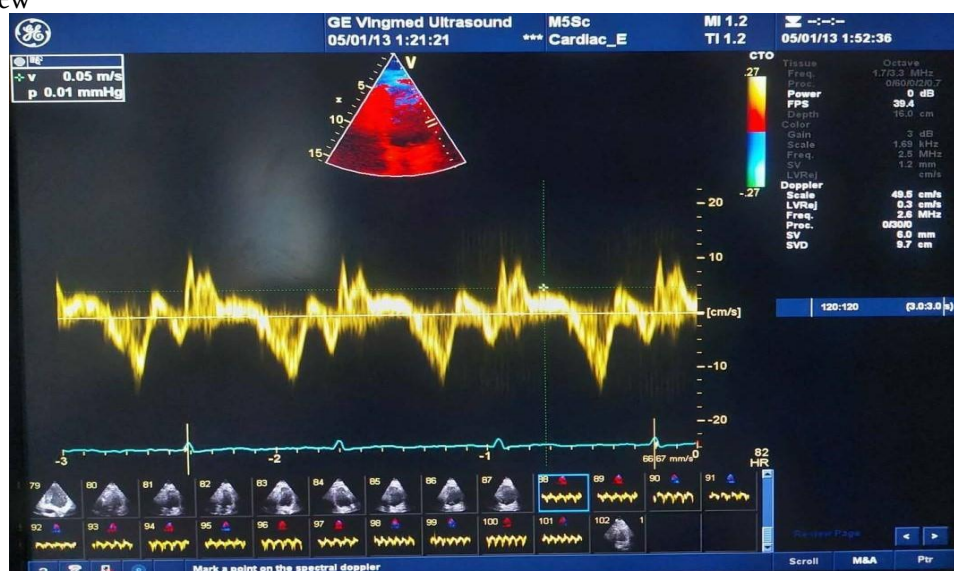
measurement of $S^{\wedge}$ of anterior wall using TDI and PW from apical 2 chamber view
